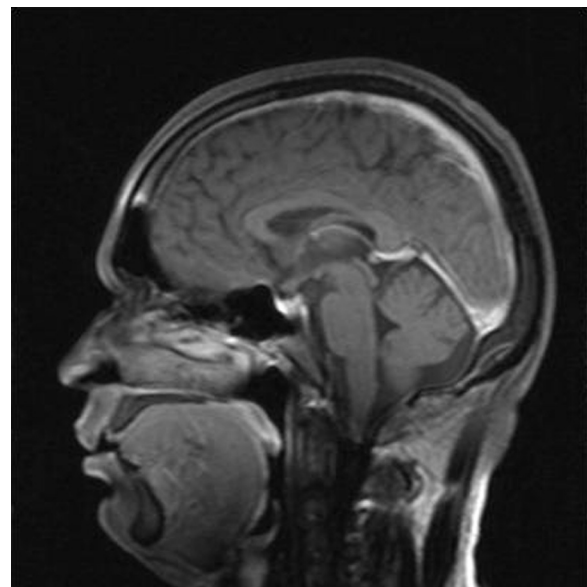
Follow up post treatment contrast enhanced MRI brain (Sagittal view) showing resolution of the pituitary mass.
